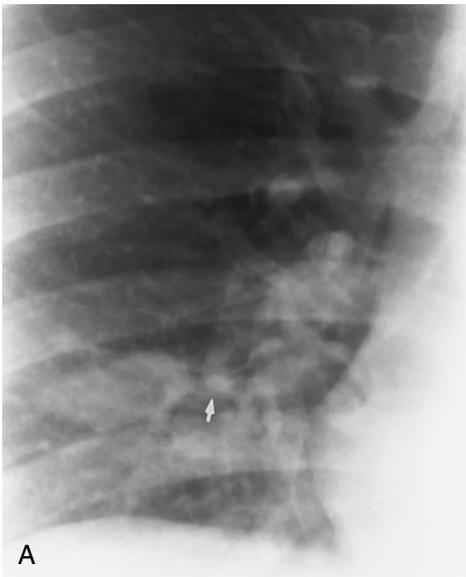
Histoplasmosis with broncholith. (A) Coned PA chest radiograph demonstrates a subtle ovoid opacity just above the diaphragm. A small calcification (arrow) lies just medial to the opacity. (B) Chest CT image (lung window) through opacity demonstrates a small calcification at the posteromedial aspect of the opacity. Calcification represents a broncholith (arrow) within a subsegmental bronchus of the right middle lobe.
